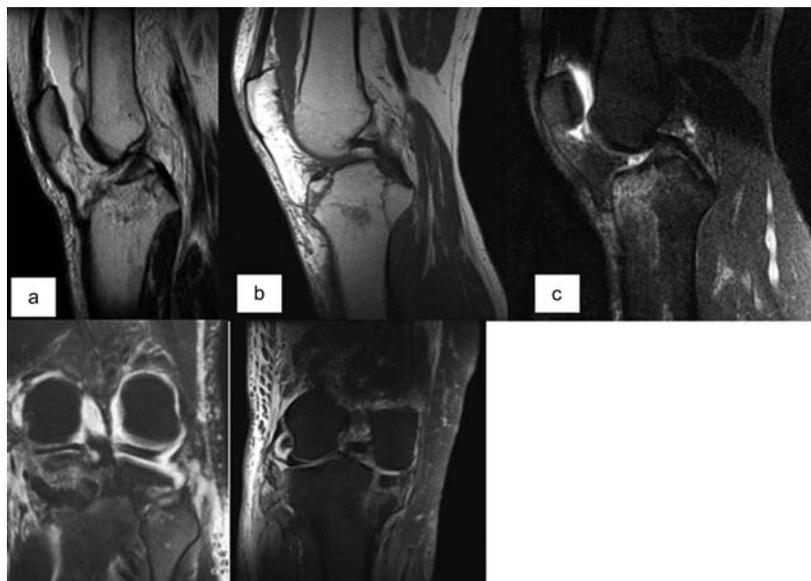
MRI findings, with intact PCL in all cases.
